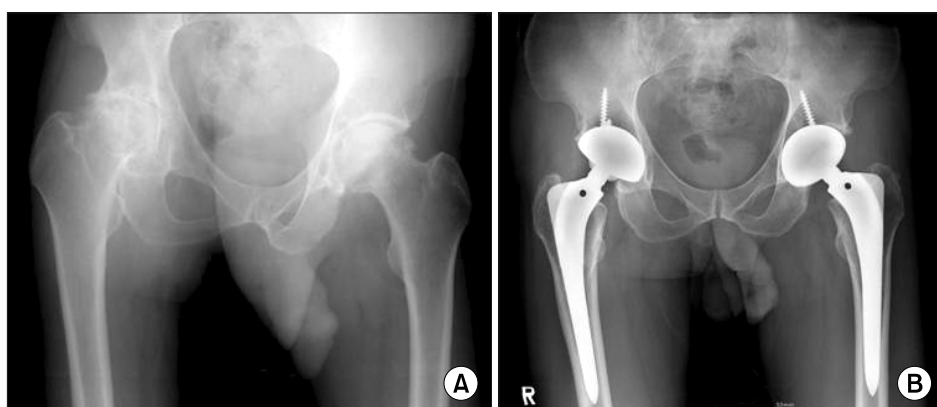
Preoperative and postoperative X-ray of one osteonecrosis patient. The postoperative X-ray shows no evidence of complications, such as loosening or infection.
